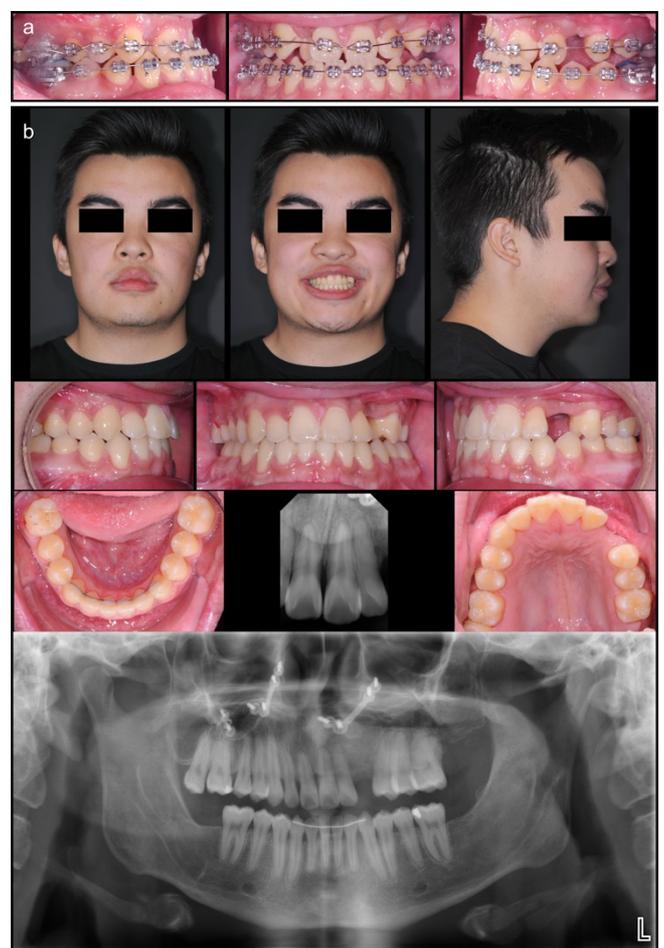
(a) MBT brackets bonded on the upper and lower teeth. (b) Extra- and intra-oral photos as well as the routine radiographic records taken after the removal of the orthodontic brackets.
